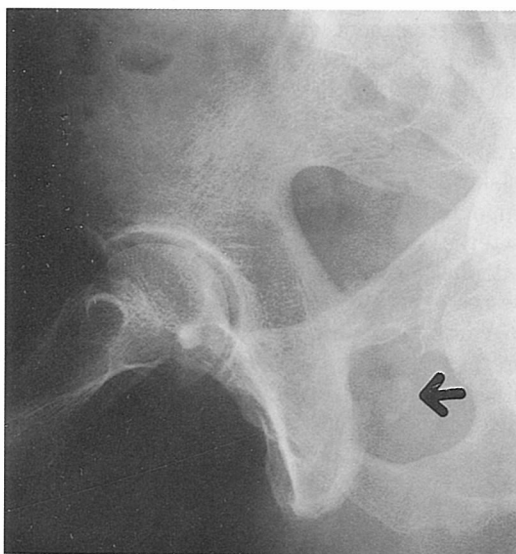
Plain radiograph shows a calcified shadow (2.0×1.5 cm) under the pubis, suggesting a urethral stone lodged in the prostatic urethra or a prostatic stone.
